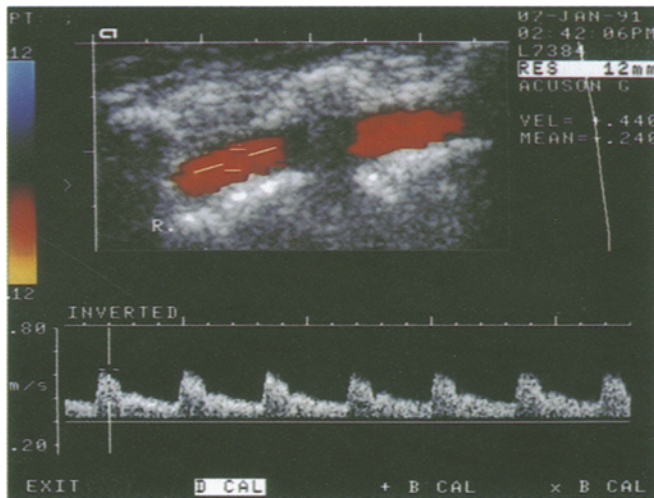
Doppler sample volume within the red-colored vertebral artery. Periodic shadowing from the cervical spine. Doppler spectra from normal vertebral artery
